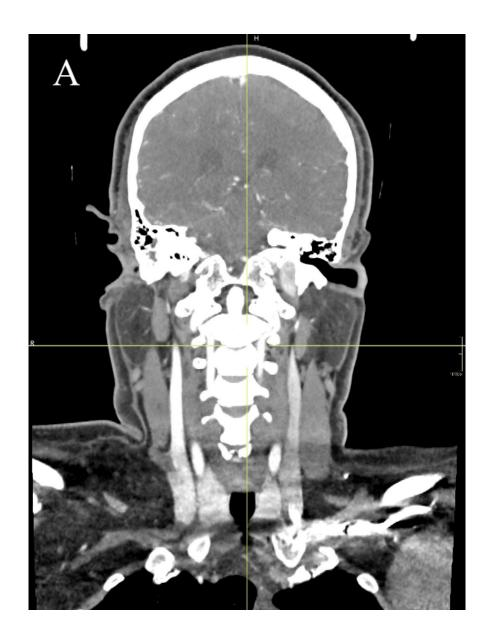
CT Angiogram shows A) Retrograde filling of right internal jugular vein due to right sided vertebrosigmoid fistula.B) Pooling of contrast within post-surgical collection representing large pseudoaneurysm.
